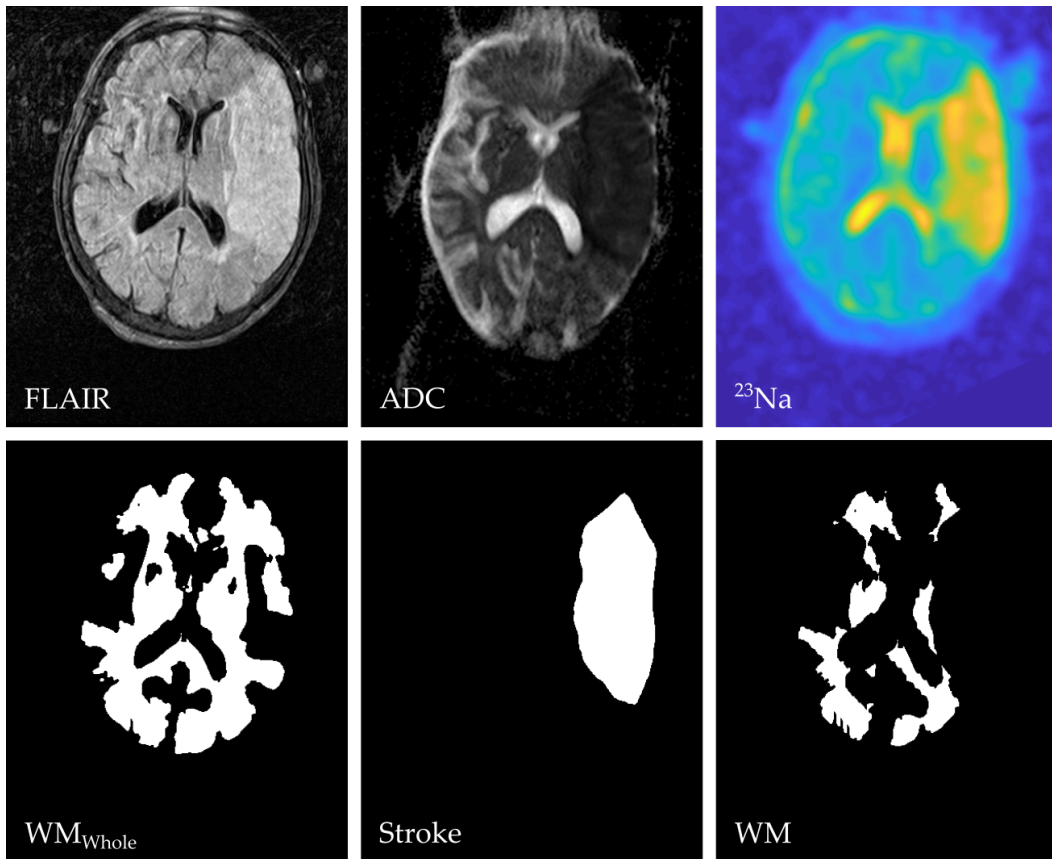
Top: One representative, transverse image slice of one patient with its  $^1\text{H}$  FLAIR (left), the co-registered  $^1\text{H}$  ADC-map (middle) and the co-registered  $^{23}\text{Na}$  MR image (right). Bottom: The corresponding masks of the automatically segmented WM ( $\text{WM}_{\text{whole}}$ , left), the manually segmented stroke mask (middle) and the evaluated WM mask (right), which was calculated by subtraction of the two other masks with an additional cut-off of the outer 4 mm border.
